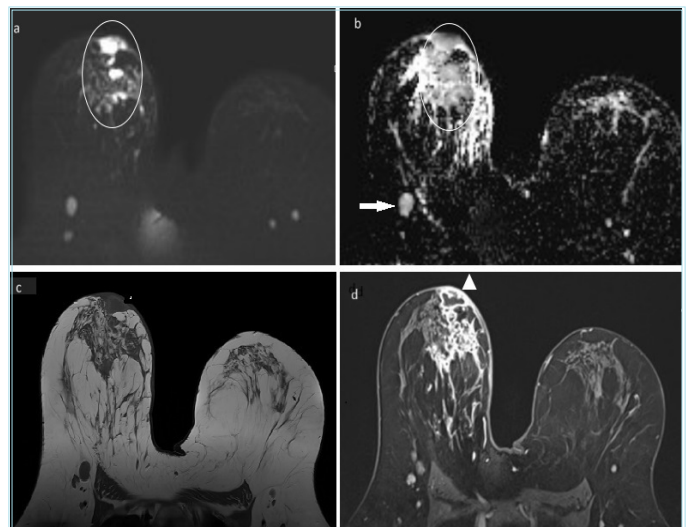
In the dynamic contrast-enhanced magnetic resonance images of a 30-year-old female patient, diffusion-weighted images (a) and ADC images (b) show diffusion restrictions in the abscess foci in the left breast (circled), which appear to be coalescing. In the T1W pre-contrast (c) and post-contrast series (d), peripheral enhancement is observed in the abscess foci (arrowhead), along with heterogeneously irregularly shaped enhancing lesions in other sections. Additionally, a few reactive lymph nodes are observed in the left axillary tail (arrow)
